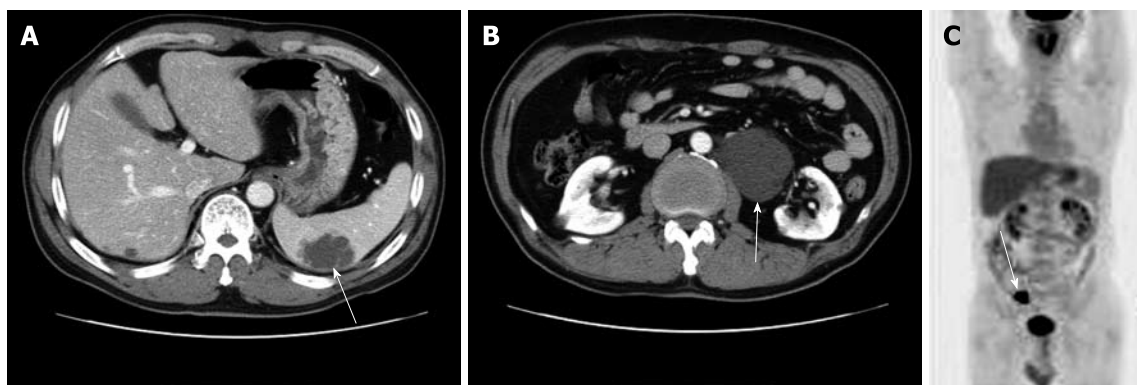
Enhanced abdominal CT and F-18 FDG Torso PET CT images of lymphangioma. A: A 5.7 cm lobulated & septated mass without enhancement in the spleen (white arrow); B: A 10 cm lobulated cystic mass in the paraaortic area (white arrow); C: A hypermetabolic lesion in the sigmoid colon mass (white arrow) and maxSUV 23 but no hypermetabolic lesion in the spleen and retroperitoneum.
